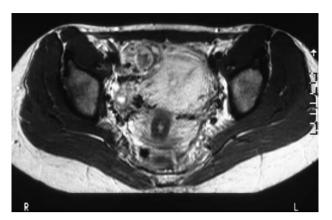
Triplet cornual pregnancy: magnetic resonance imaging confirmed the cornual localization of the three gestational sacs in the right uterine 'horn'
